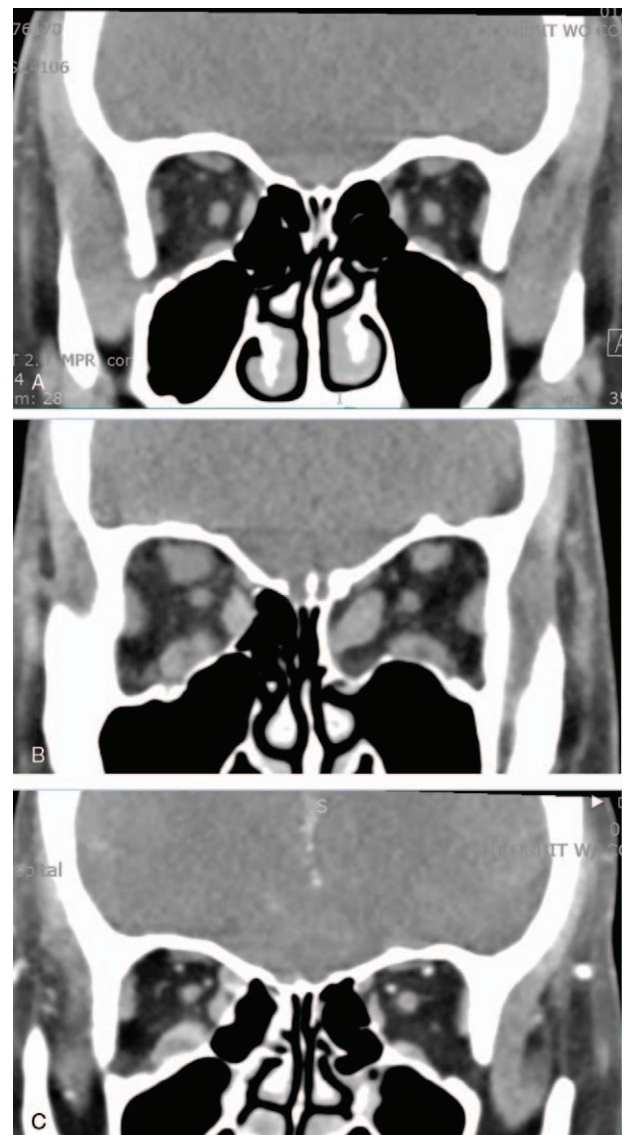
Computed tomography of patients 1 (A), 2 (B), and 3 (C). Note the relative mild muscle enlargement, suggesting that the proptosis related primarily to fat hypertrophy.
